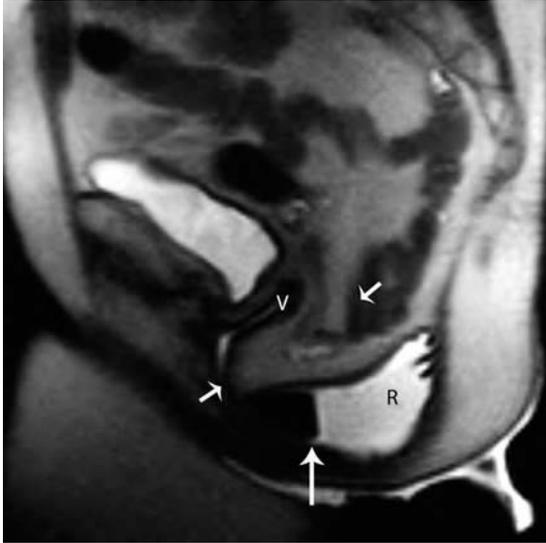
Cul-de-sac defect in a 74-year-old female. Sagittal T2-weighted SSFSE image obtained during Valsalva maneuver reveals descent of the sigmoid colon and peritoneal fat (short arrows) into the rectovaginal space. Also note an anterior rectocele (long arrow). V, vaginal canal; R, rectum.
